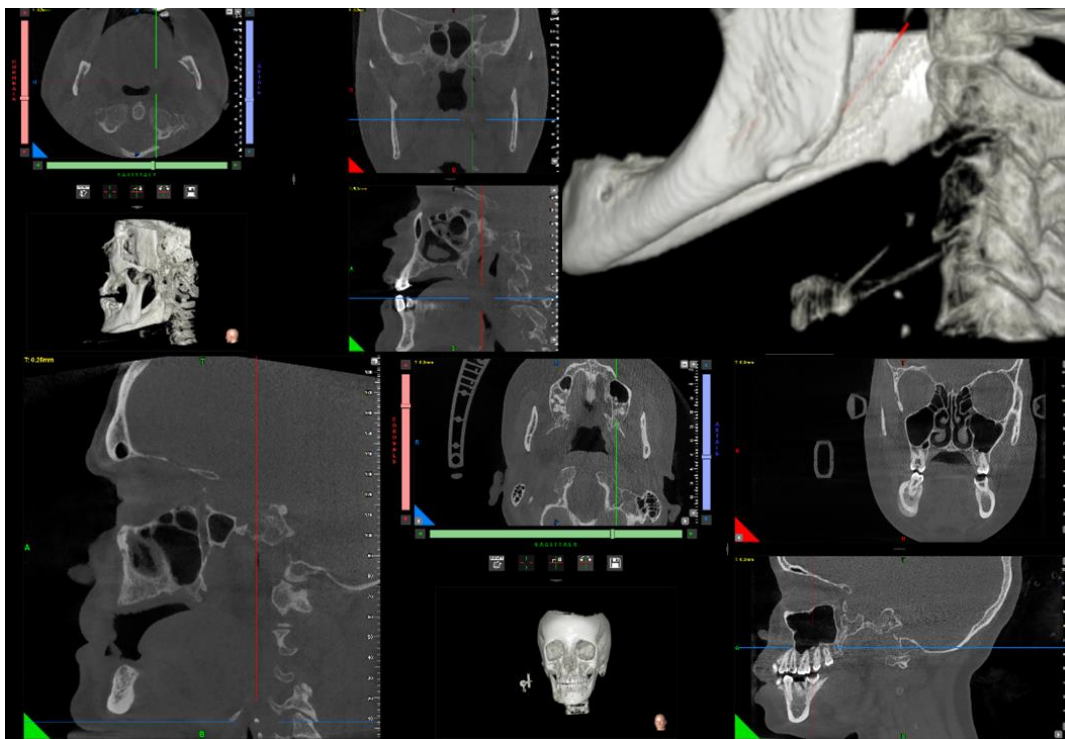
CBCT Image of Soft Tissue Calsifications. Tonsillolith, Carotis Artery Calsifications, Anthrolith.
